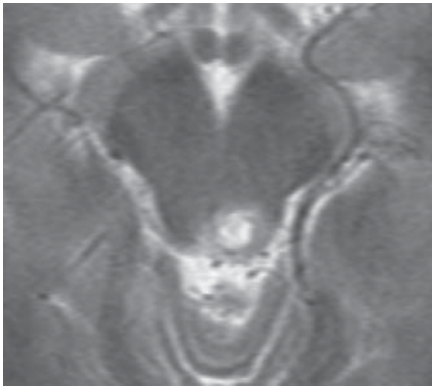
MRI of the brain on 25.01.2005, T2 TSE axial (TR 3692, TE 96). Strong T2 hyperintense lesion in the left colliculus inferior, small hypointense rim, discrete hypointense internal structure, slight to moderate perifocal edema.
